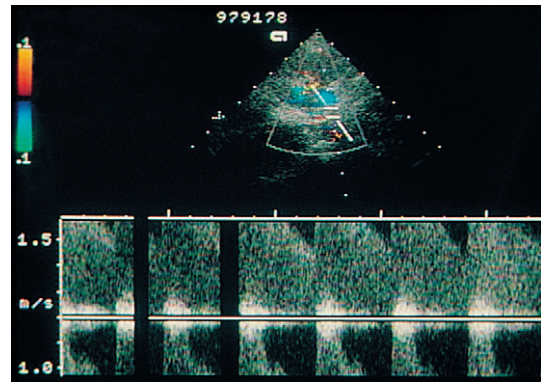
(a) Right renal artery stenosis. There is increased flow velocity with a aliasing of the Doppler spectrum. (b) Right renal artery stenosis. Patient presented with flash pulmonary oedema. Only a single heart cycle is demonstrated because of the dyspnoea. Peak flow velocity within the right renal artery is 240 cm s^{-1} .
